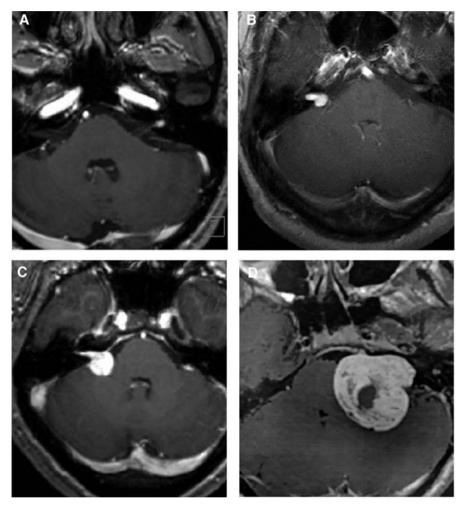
T1-weighted MRI with contrast enhancement showing the 4 stages of VS growth (A-D)
